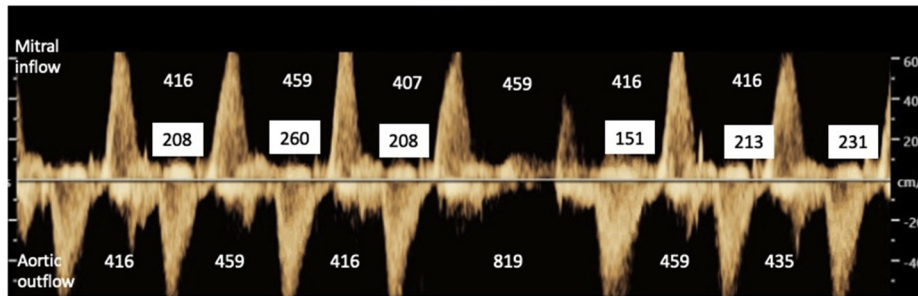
Fetal spectral Doppler showing atypical Wenckebach periodicity in type 1 second-degree atrioventricular (AV) block at 36 5/7 weeks. Mitral inflow (above baseline) / aortic outflow (below baseline) spectral Doppler. There is fusion of mitral E and A waves. From left to right: The AV interval (white boxes) prolongs from 208 to 260 ms, then shortens to 208 ms prior to the nonconducted atrial beat (atypical Wenckebach periodicity). Atrial cycle length (top row of numbers) is variable, but the shortest is >80% of the average cycle length, suggesting absence of premature atrial contractions.¹⁴ Ventricular cycle length ranges from 416 to 819 ms (bottom row of numbers).
